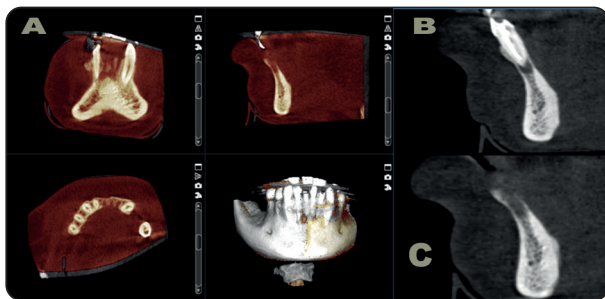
A: Superimposed pre- and post-operative CBCT scans. Same cut is displayed in both pre- (B) and post-operative (C) CBCT scans.
